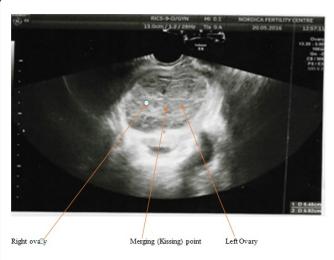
Ultra-sonography appearance of kissing ovaries.
